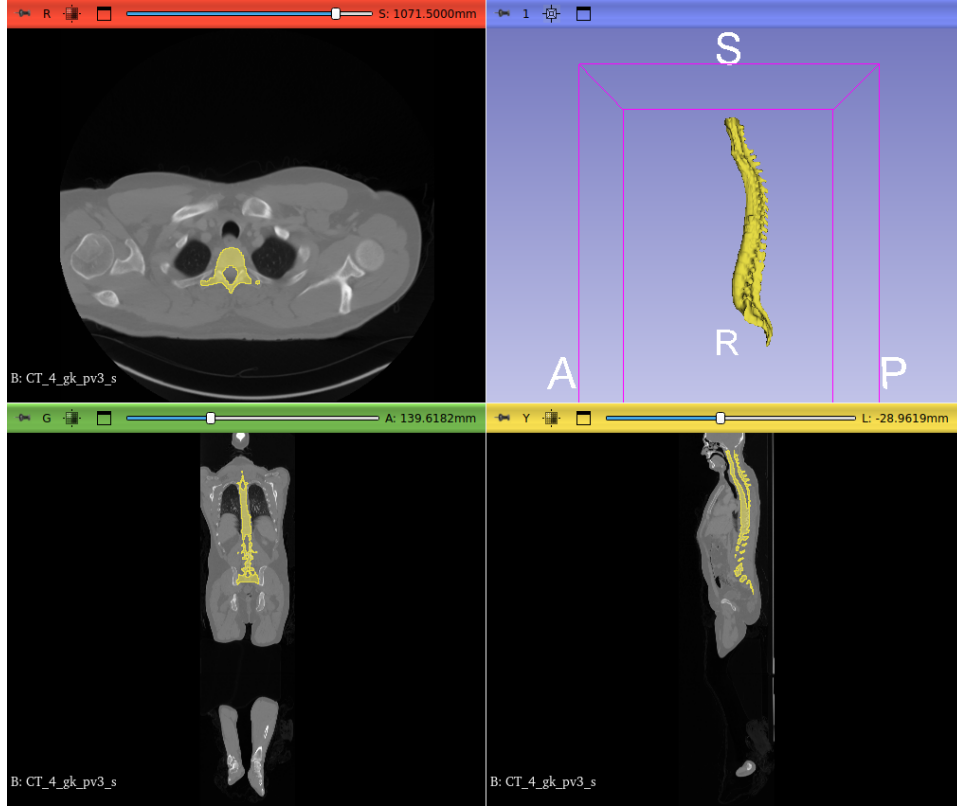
Example of MOOSE binarization. In the image are represented a CT image (black and white) and an example of bone segmentation binarized (yellow), projected on the three medical imaging planes and on top right a 3D segmentation rendering. It is clear that from the complete skeleton segmentation, just the spine is conserved, specified by a unique label. The original image comes from TCIA public dataset, and they are visualized with 3D Slicer software.
